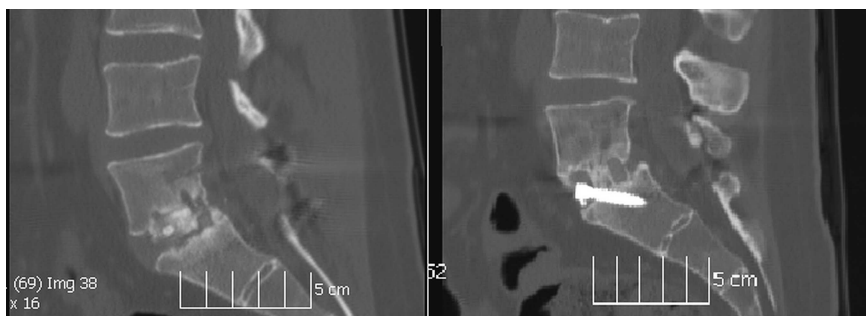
Sagittal CT scans comparing an Actifuse-treated patient with a pseudarthrosis at L5–S1 (left) and the ALIF revision using rhBMP-2 (right). CT indicates computed tomography; ALIF, anterior lumbar interbody fusion.
